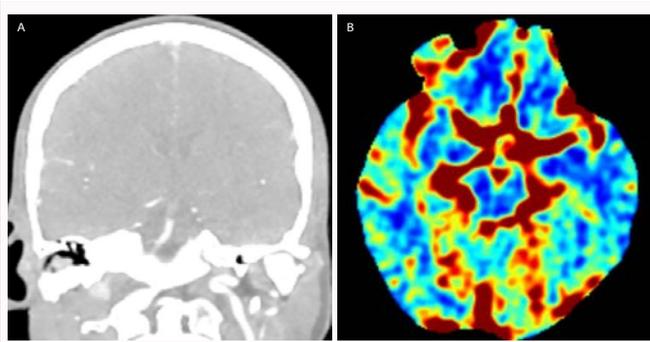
(A) CT Angiogram: Showed a top-of-basilar occlusion. (B) CT Perfusion showed no established infarction.
